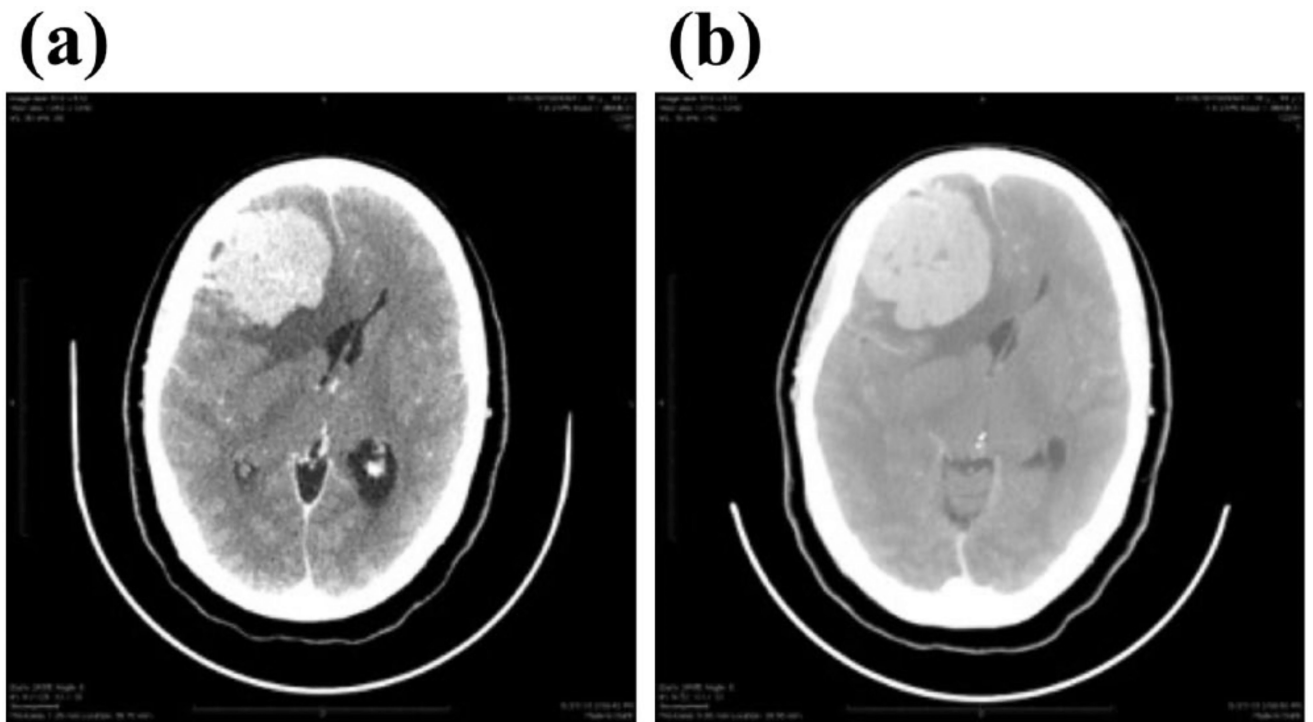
Axial postcontrast computed tomography scans with (a) soft tissue window and (b) air window demonstrate significant midline shift from meningioma. A large lobulated enhancing mass is along the right frontal lobe, with surrounding vasogenic edema and associated mass effect due to effacement of the frontal horn of the right lateral ventricle and midline shift.
